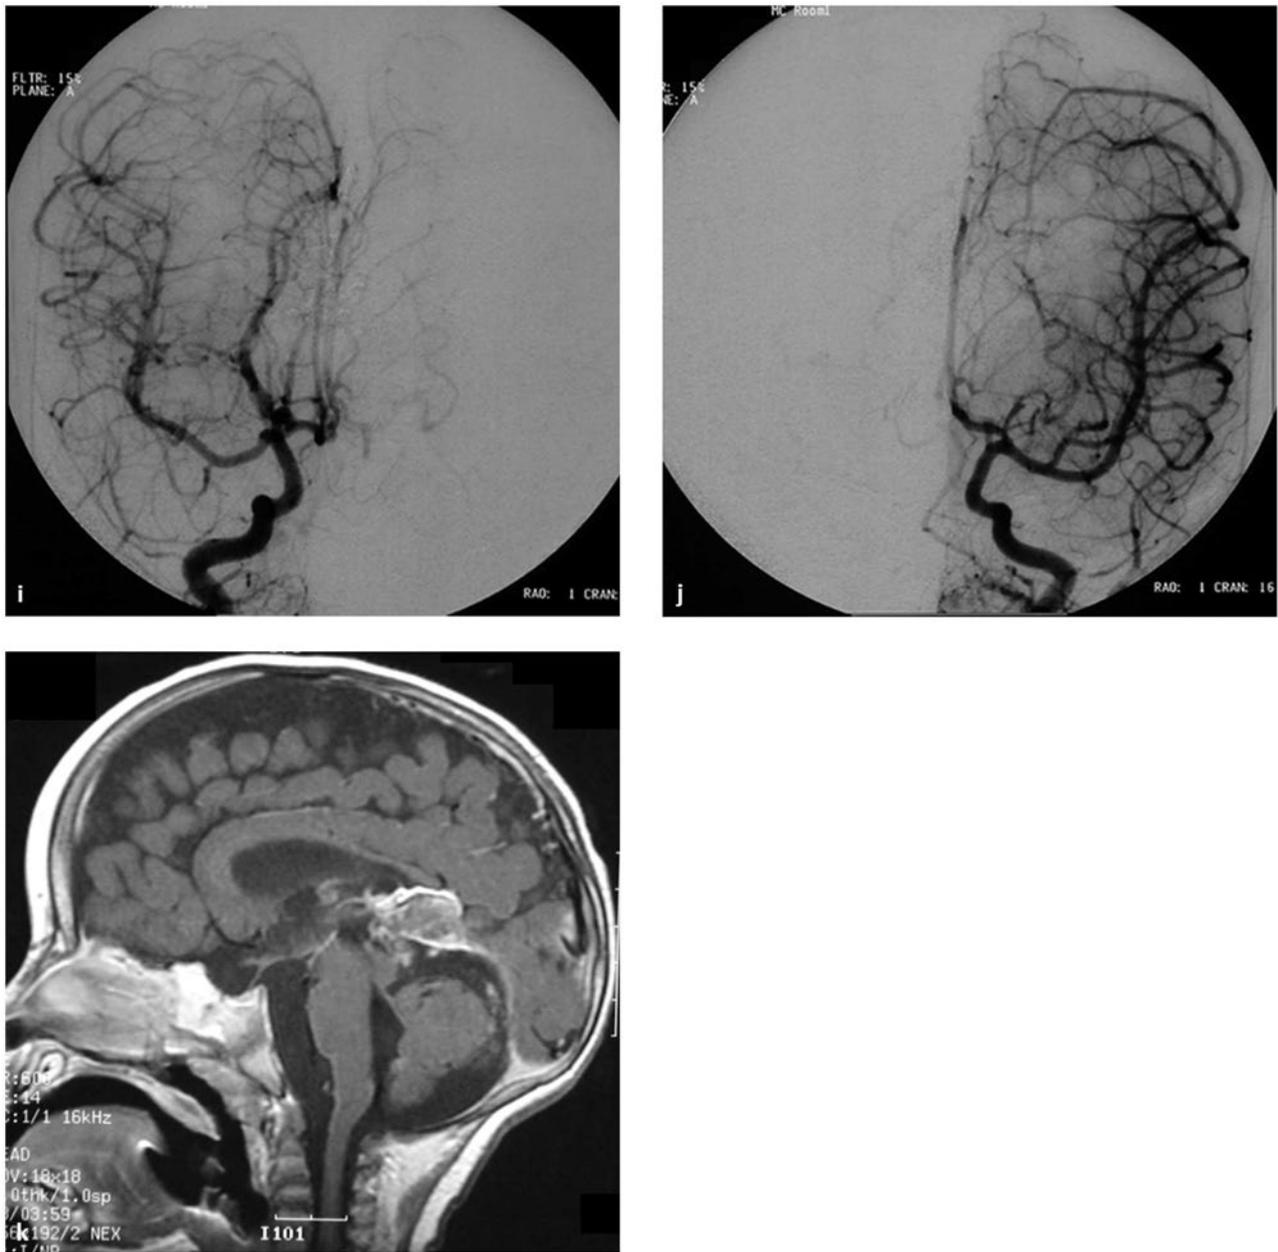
(continued) (i) Right and (j) left common carotid artery angiograms in the AP view demonstrate no opacification of the fistulas. Distal posterior cerebral arteries were opacified through the posterior communicating artery bilaterally. The patient remained with moderate developmental delay. (k) T1-weighted sagittal magnetic resonance imaging with contrast 2 days after the third embolization demonstrates thrombosis and shrinkage of the median vein of the prosencephalon and the embryonic falcine sinus.
